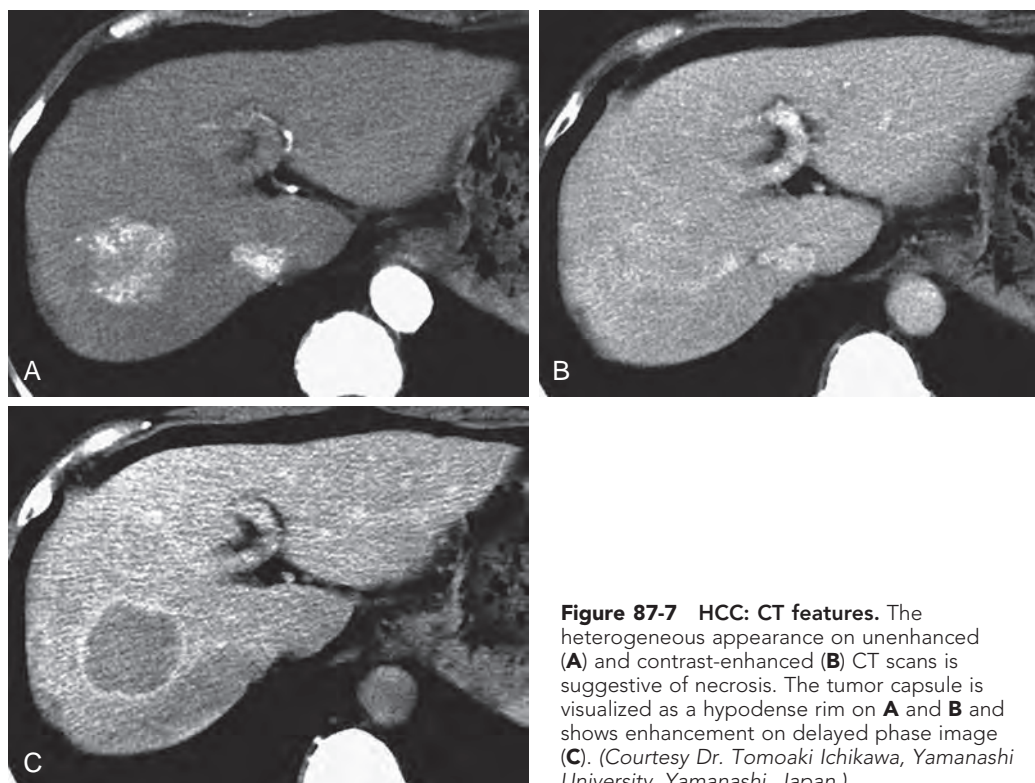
HCC: CT features. The heterogeneous appearance on unenhanced (A) and contrast-enhanced (B) CT scans is suggestive of necrosis. The tumor capsule is visualized as a hypodense rim on A and B and shows enhancement on delayed phase image (C). (Courtesy Dr. Tomoaki Ichikawa, Yamanashi University, Yamanashi, Japan.)
